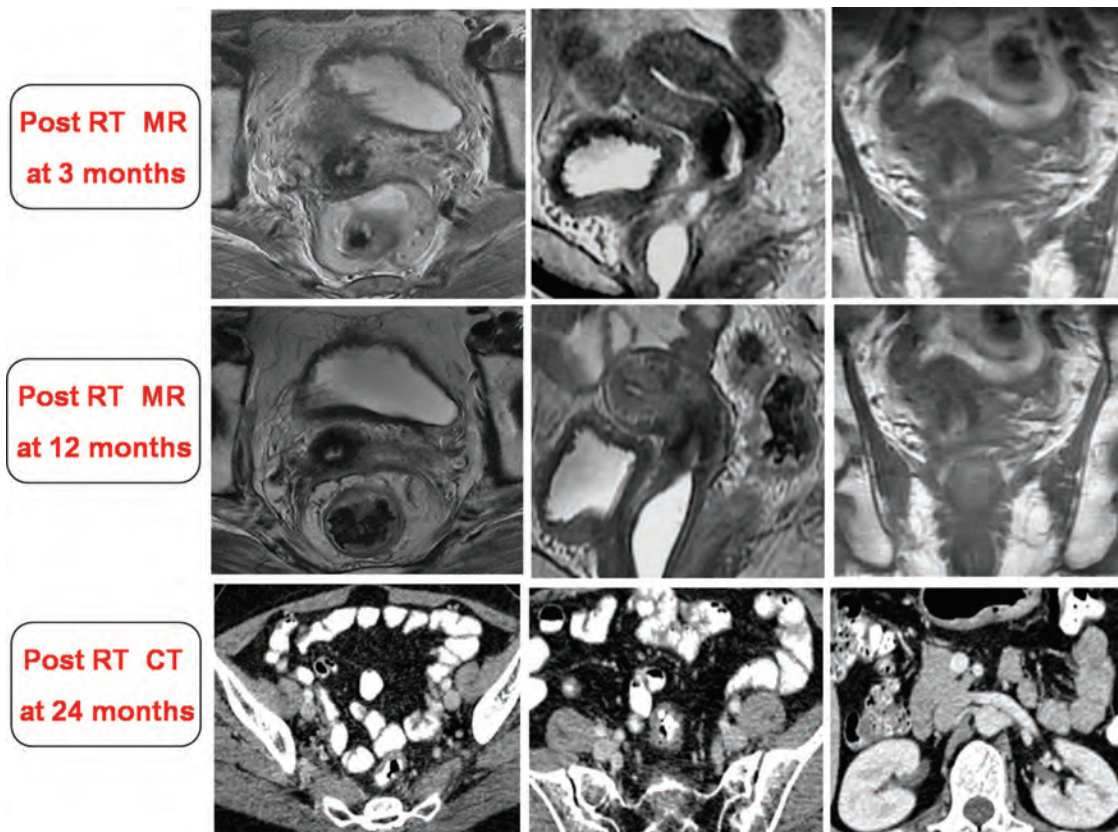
Representative MR at 3 months, 12 months, and CT at 24 months. Representative axial, sagittal, and coronal images of MR at 3 months showing complete response; MR at 12 months showing right parametrial fibrosis and CT (axial slices only) at 24 months showing no evidence of pelvic or para-aortic lymphadenopathy.
